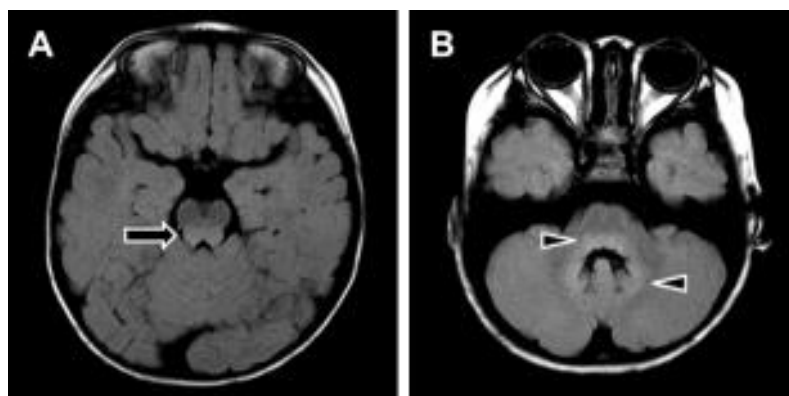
Brain magnetic resonance imaging findings in a patient with enterovirus 71 brainstem encephalitis. (A) Note the high signal-intensity lesion in the posterior aspect of the midbrain (arrow). (B) Note the high signal-intensity lesion in the posterior aspect of the pons and the bilateral dentate nuclei of the cerebellum (arrowheads).
